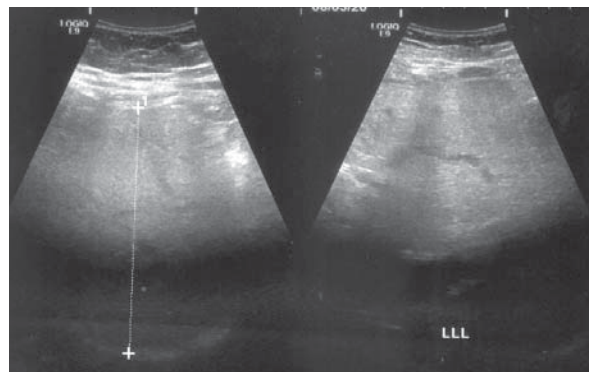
Ultrasound image of the liver (08/03/2020)
